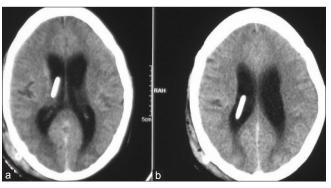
CT scan after right ventriculoperitoneal shunt demonstrated shunt tip *in situ* with decompressed ventricles
